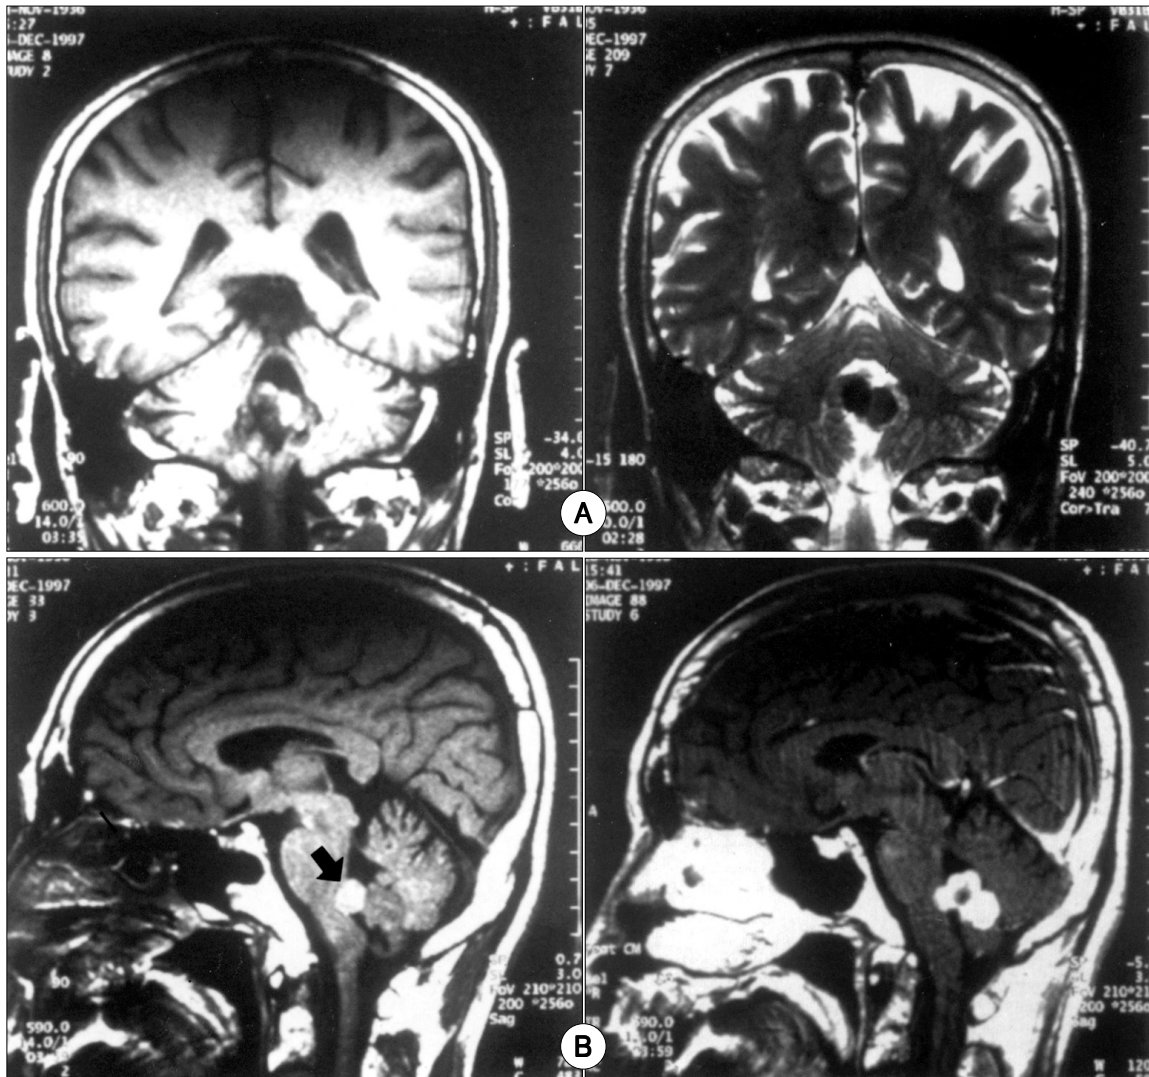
A : T1 and T2 coronal magnetic resonance images(upper). B : Sagittal magnetic resonance images before and after Gadolinium injection(lower). A mass lesion displacing the brain stem anteriorly and cerebellar tonsils inferiorly through the foramen magnum is seen in the inferior part of the fourth ventricle. The lobulated mass is homogenously enhanced with Gadolinium. Hemorrhagic dot(arrow) is associated with tumor.
